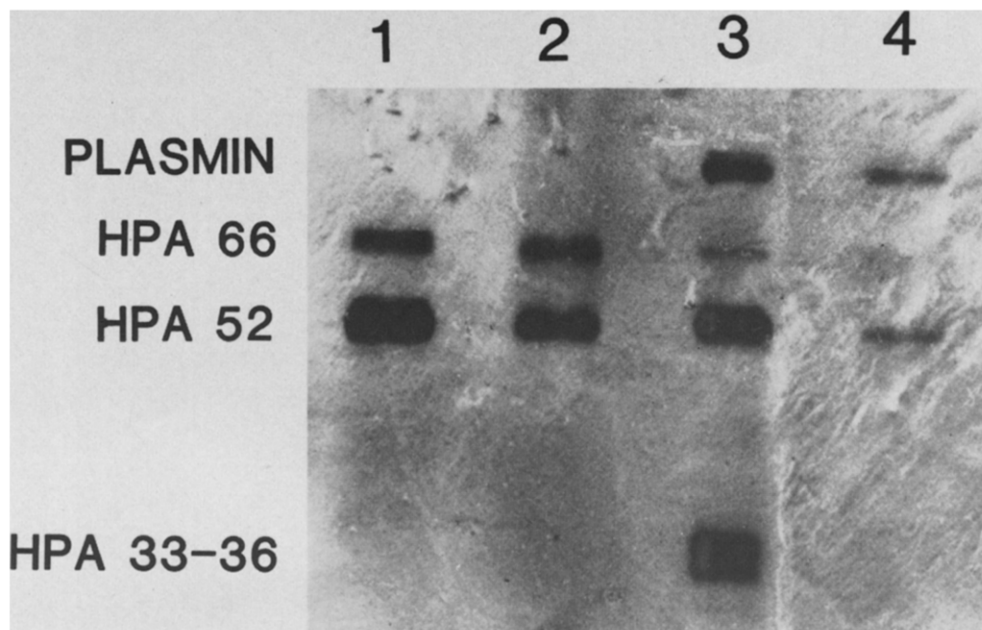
The effect of minactivin on plasminogen activators in a sample of colon cancer homogenate. Lane 1 shows the untreated sample. Lane 2 shows the effect of preincubation for 60 min at 23° C (titration equivalent of 1.4 CTA U urokinase) with minactivin. Lane 3 represents the effect of preincubation for 30 min at 37° with human plasminogen and then for 60 min at 23° with control buffer. In lane 4, the homogenate was preincubated for 30 min at 37° C with plasminogen, and then exposed to minactivin for 60 min at 23° C. Zones of lysis are: plasmin M, 85,000; HPA66; HPA52 and HPA 33-36.
